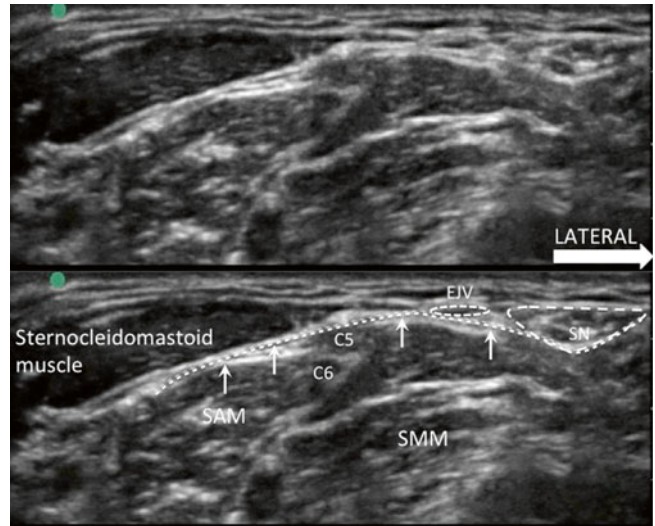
Sonogram of the supraclavicular nerve (SN). The top picture is the unlabeled version of the bottom picture. Note the investing layer of the deep cervical fascia (dotted line indicated by arrows). The SN is superficial to this layer and is in close proximity with external jugular vein (EJV). SAM scalenus anterior muscle, SMM scalenus medius muscle (Reproduced with permission from Philip Peng Education Series)
